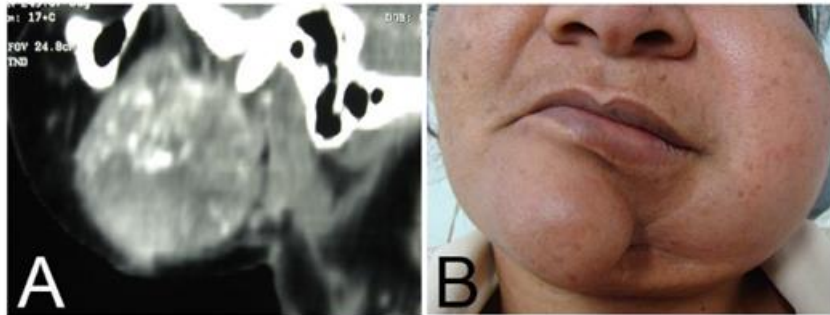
A. Sagittal contrast-enhanced CT reconstruction, showing signs of lesion recurrence with a characteristic “sunshine” appearance, due to the production of osteoid tissue. B. Extraoral view with marked asymmetry on the left side, seven months after surgery.
